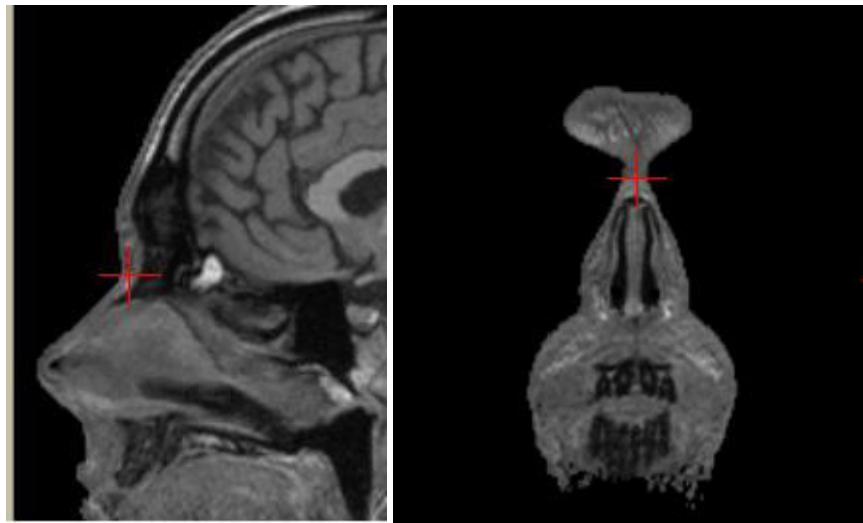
Nasion landmark location sagittal and coronal MRI views
